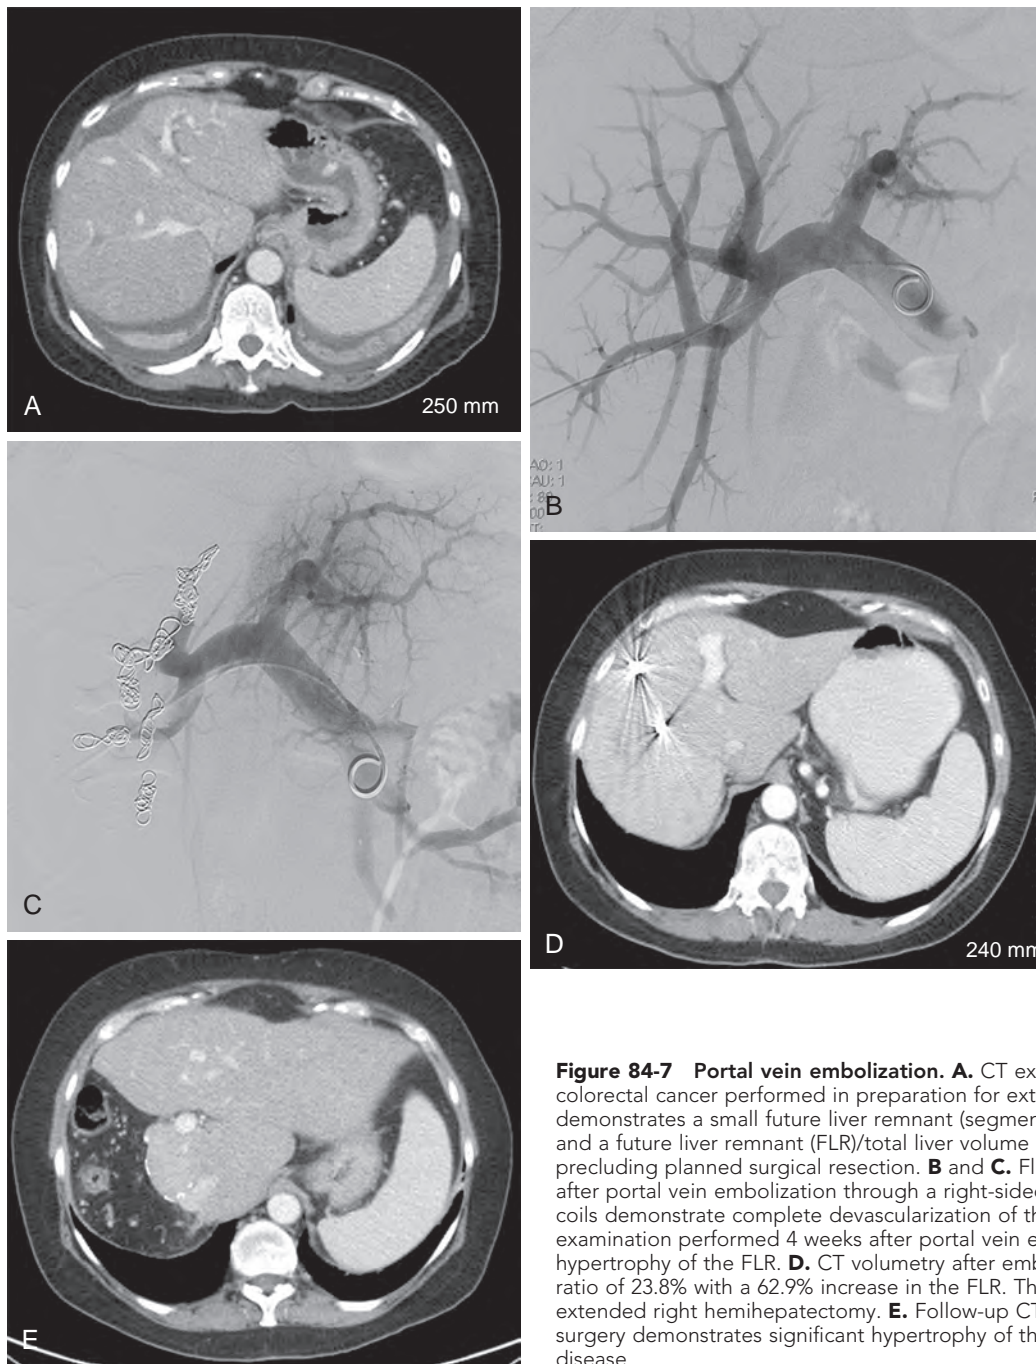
Portal vein embolization. A. CT examination in a patient with metastatic colorectal cancer performed in preparation for extended right hepatectomy demonstrates a small future liver remnant (segments I-III). CT volumetry was performed, and a future liver remnant (FLR)/total liver volume (TLV) ratio was calculated at 15.2%, precluding planned surgical resection. B and C. Fluoroscopic images before and after portal vein embolization through a right-sided approach with particles and coils demonstrate complete devascularization of the right hemiliver. Follow-up CT examination performed 4 weeks after portal vein embolization demonstrates significant hypertrophy of the FLR. D. CT volumetry after embolization demonstrated an FLR/TLV ratio of 23.8% with a 62.9% increase in the FLR. The patient underwent the planned extended right hemihepatectomy. E. Follow-up CT examination performed 2 years after surgery demonstrates significant hypertrophy of the liver remnant without recurrent disease.
